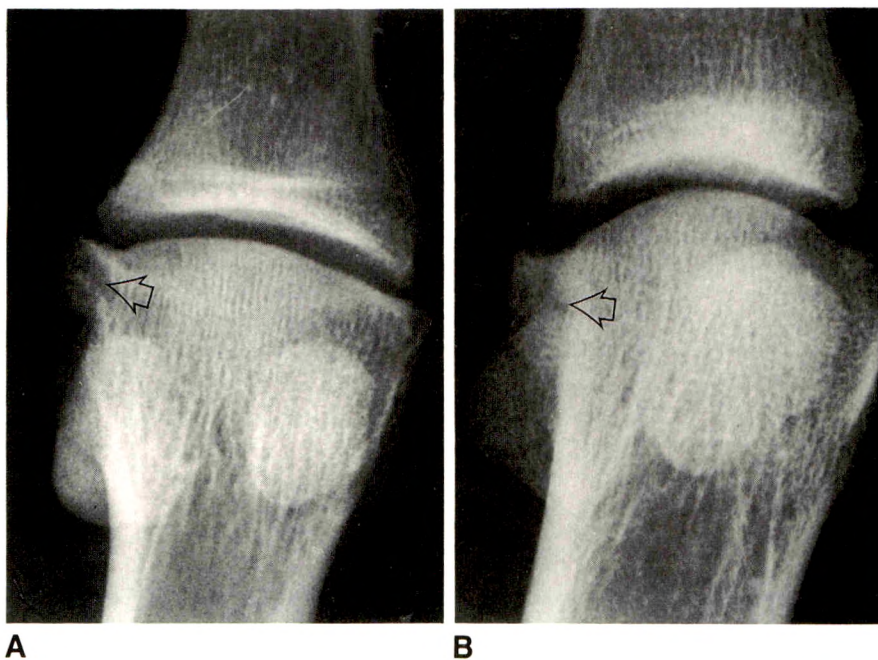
A and B, Mild hallux rigidus (grade 1). Anteroposterior radiographs of two examples show minimal metatarsophalangeal joint-space narrowing and lateral bone spurs (arrows).
